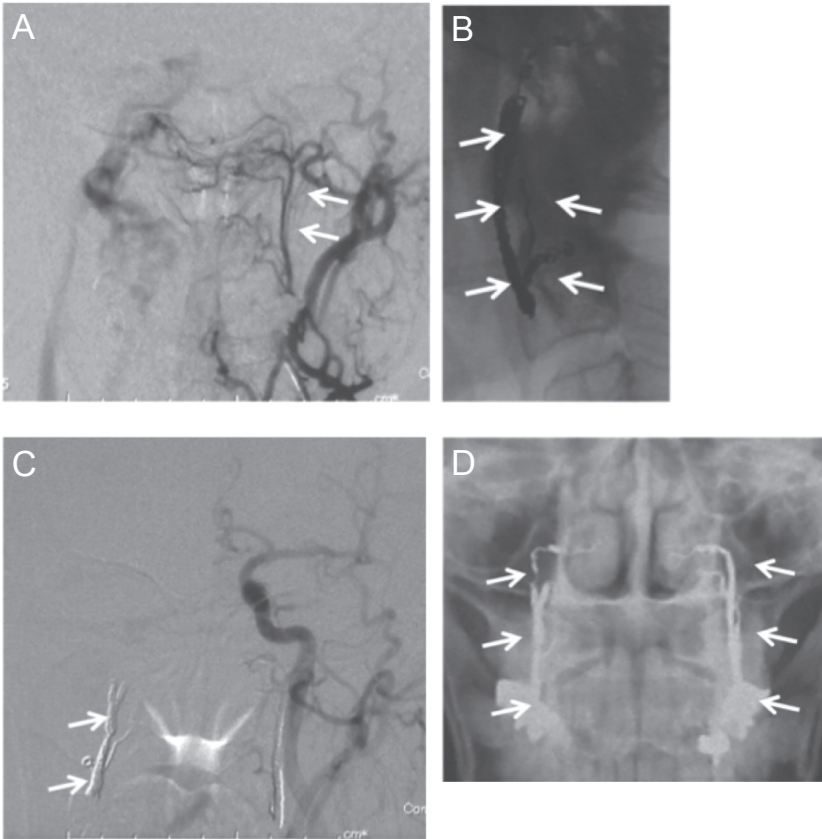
A 62-year-old man with anterior condylar confluence dural AVF treated by transarterial embolization. A: Anterior-posterior view of left external carotid angiography showed anterior condylar confluence dural AVF fed by the left ascending pharyngeal artery (*arrow*), B: Lateral view of unsubtracted image during embolization. Three CSCs were placed to the left ascending pharyngeal artery (*arrow*), C: Postoperative control angiography showed CSCs (*arrow*) and obliteration of the dural AVF, D: Skull X-ray showing coil nest in the bilateral ascending pharyngeal arteries (*arrow*). AVF: arteriovenous fistula, CSC: c-stopper coil.
